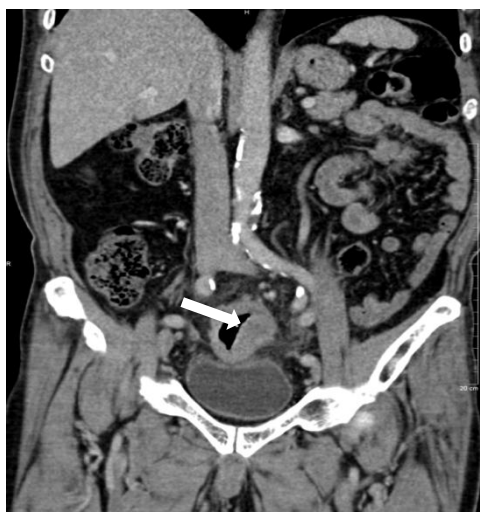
case3: Contrast-enhanced coronal CT scan image of the pelvis showing partial bowel wall thickening and dilatation of intestine at the sigmoid colon (white solid arrow).
